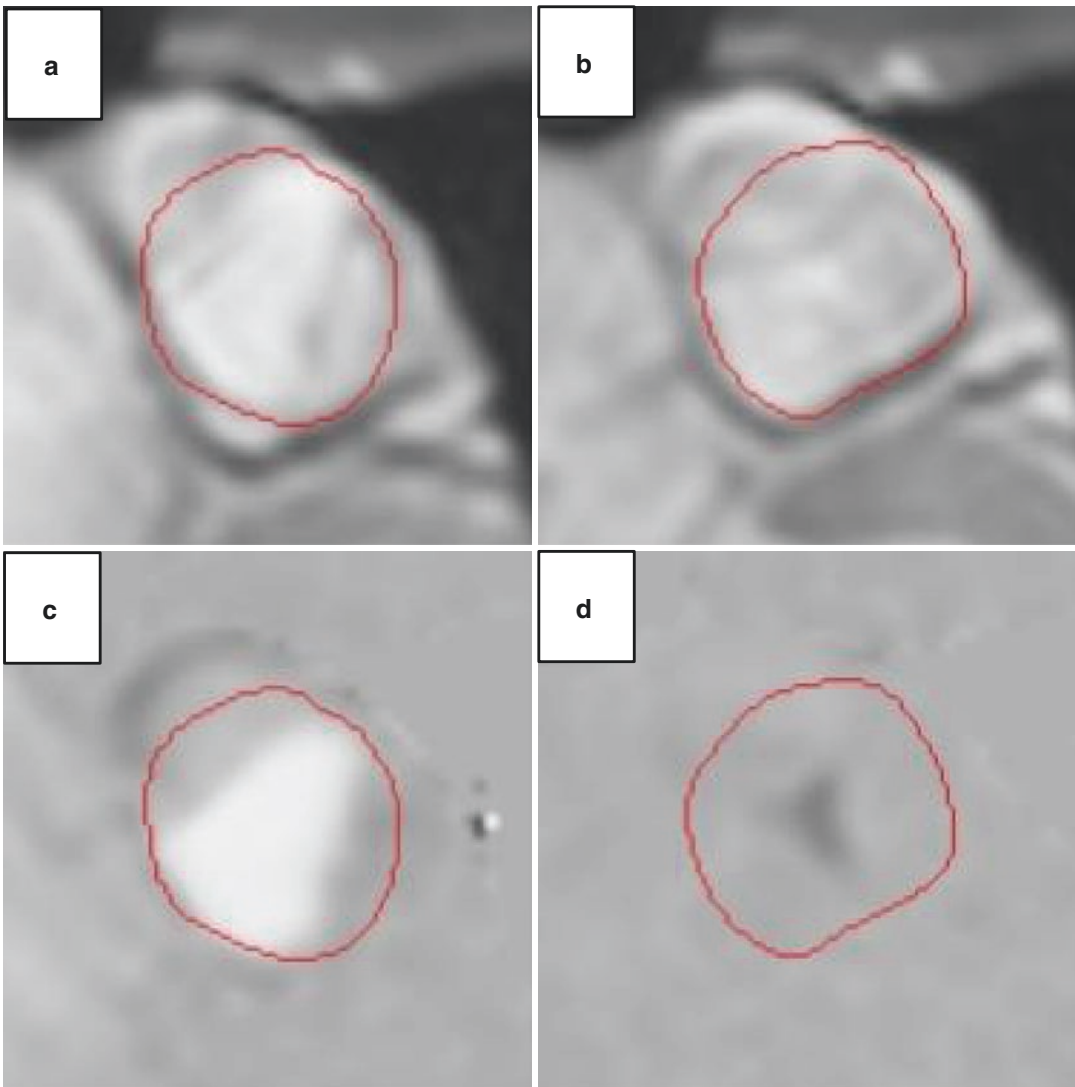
Fifty-two-year-old male with corrected TOF. MRI anatomical modulus images (a, b) and phase-contrast (PC) images (c, d) showing pulmonary valve regurgitation. Systolic forward flow (*bright signal*) in the pulmonary artery at the level of the pulmonary valve (a, c). Backward flow (note that the signal is *black*, due to opposed flow
